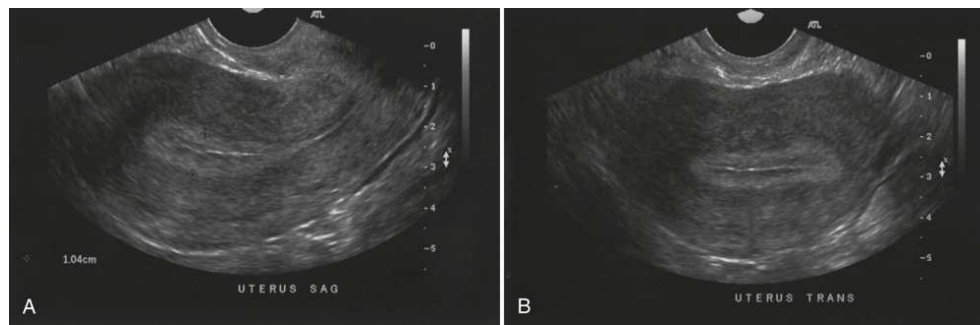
(A) Endovaginal sagittal sonogram of uterus. (B) Coronal sonogram of uterus.
